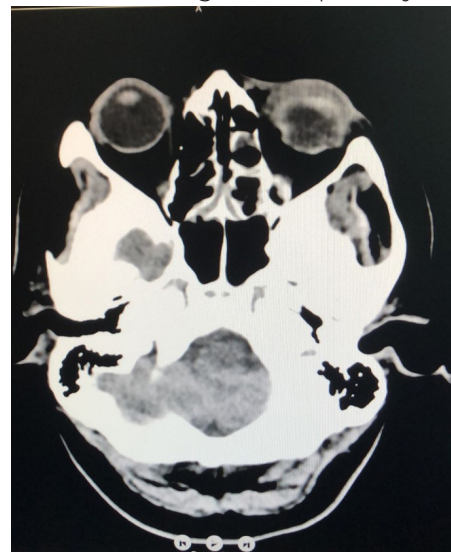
CT image of the left eye
